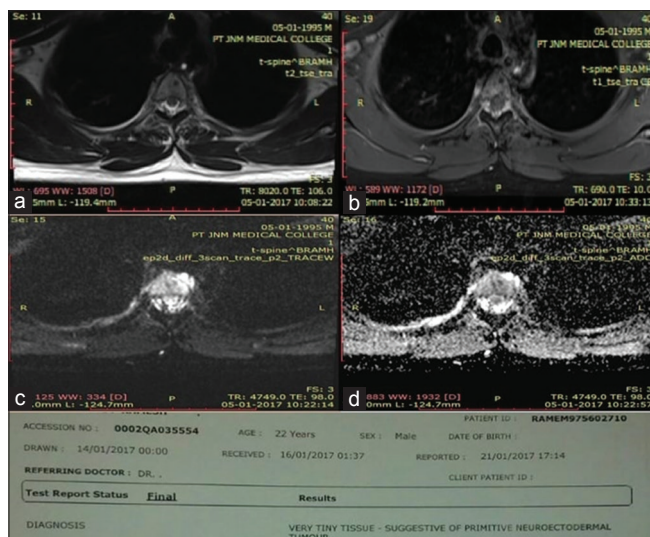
A 22-year-old man presented with bilateral paraplegia. (a) Axial T2-weighted imaging (WI) shows heterogeneous hyperintensity of T5 vertebrae. (b) Axial T1-weighted post-contrast at the level of T5 vertebrae shows heterogeneously enhancement with the involvement of posterior elements and cord compression. (c) Axial diffusion WI at same level shows diffusion restriction. (d) Corresponding axial apparent diffusion coefficient (ADC) map ($b = 0$ and 1000 s/mm^2 shows decreased signal intensity with an ADC value of 1.05 in bone). [Biopsy revealed PNET]
